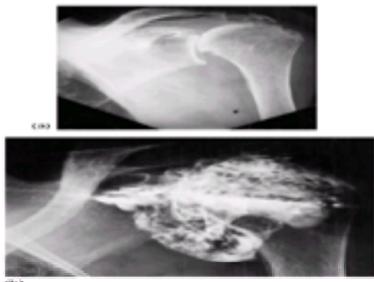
Rheumatoid arthritis with a large effusion which can be seen on the plain film. (a) Upward subluxation of the humeral head is associated with marginal erosions, as well as erosion of the under surface of the acromion. The displaced fat plane beneath the glenoid and humeral head is seen on the subsequent arthrogram to represent the margin of the distended capsule. (b) A rotator cuff tear is demonstrated at arthrography with filling of the subacromial bursa. The distended joint capsule is demonstrated, especially inferiorly. Numerous loose bodies lie within the joint space. These may represent areas of synovial proliferation or osteochondral fragments but, in the main, represent fibrinous loose bodies.
